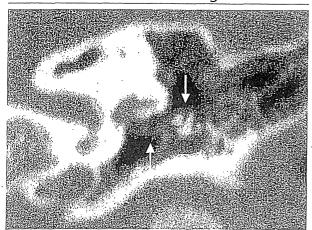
(Case 3) Left ear CT: preoperative
